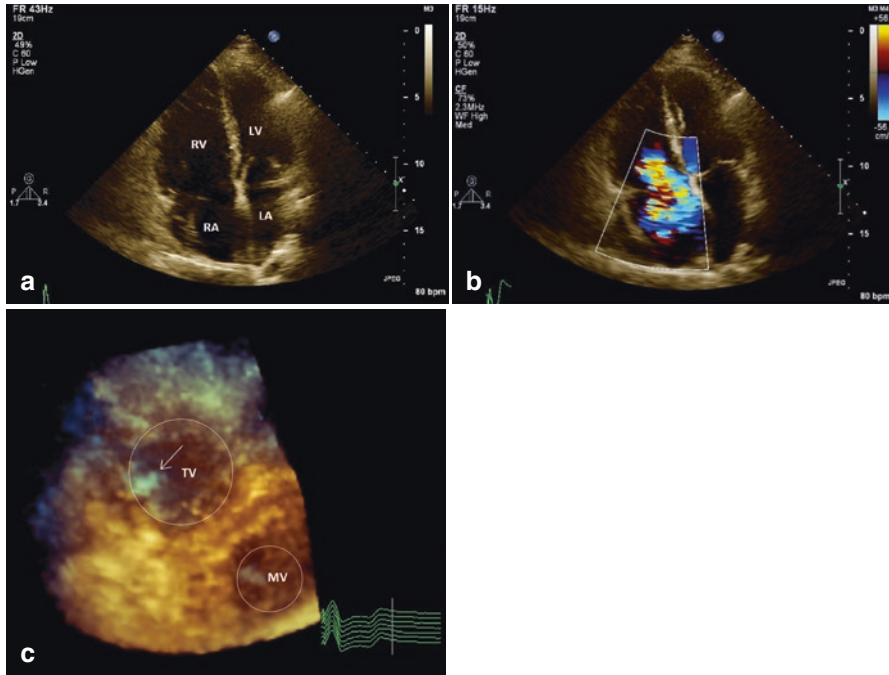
Panel (a) shows dilatation of the right ventricle and right atrium. RA dimensions are 73×59 mm, TAPSE is 21 mm. (b) Massive tricuspid regurgitation is present. (c) With 3d echocardiography the cardiac pacemaker lead can be visualized (the arrow points to the lead). MV mitral valve, TV tricuspid valve
